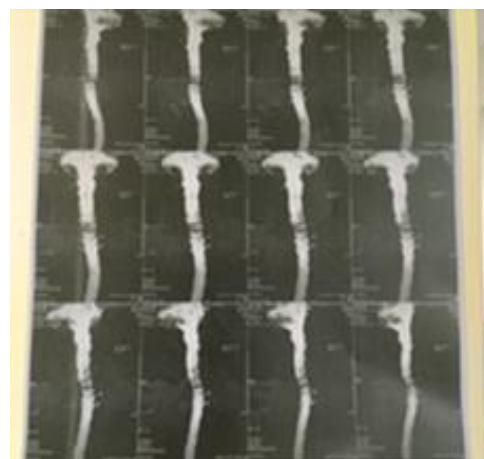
Complementary investigations confirming the diagnosis. 4b, c, d) Cervical MRI images.
